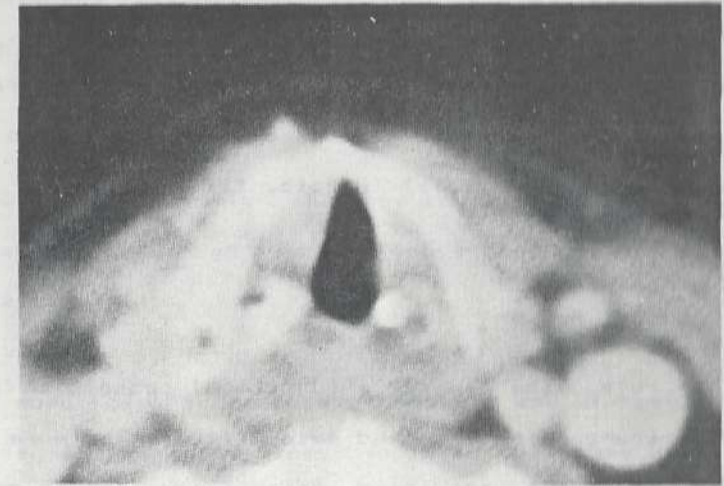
Muscular atrophy, as it is shown by a CT-scan of larynx, at the level of the right paralyzed vocal fold. In the present case, total denervation occurred five years before, and was due to strumectomy.
